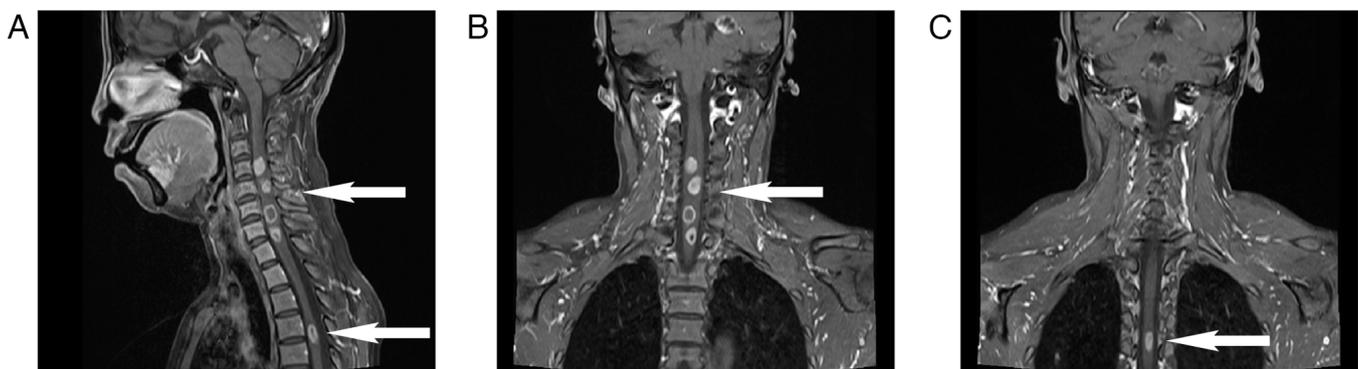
Progression imaging of the neck and thoracic spine in November 2021. (A) T2-weighted sagittal MR images revealed multiple nodules within the cervical and thoracic spinal cords (arrows). (B) T2-weighted coronal MR images showing multiple nodules within cervical spinal cords (arrow). (C) T2-weighted coronal MR images showing a nodule within thoracic spinal cords (arrow). MR, magnetic resonance.
